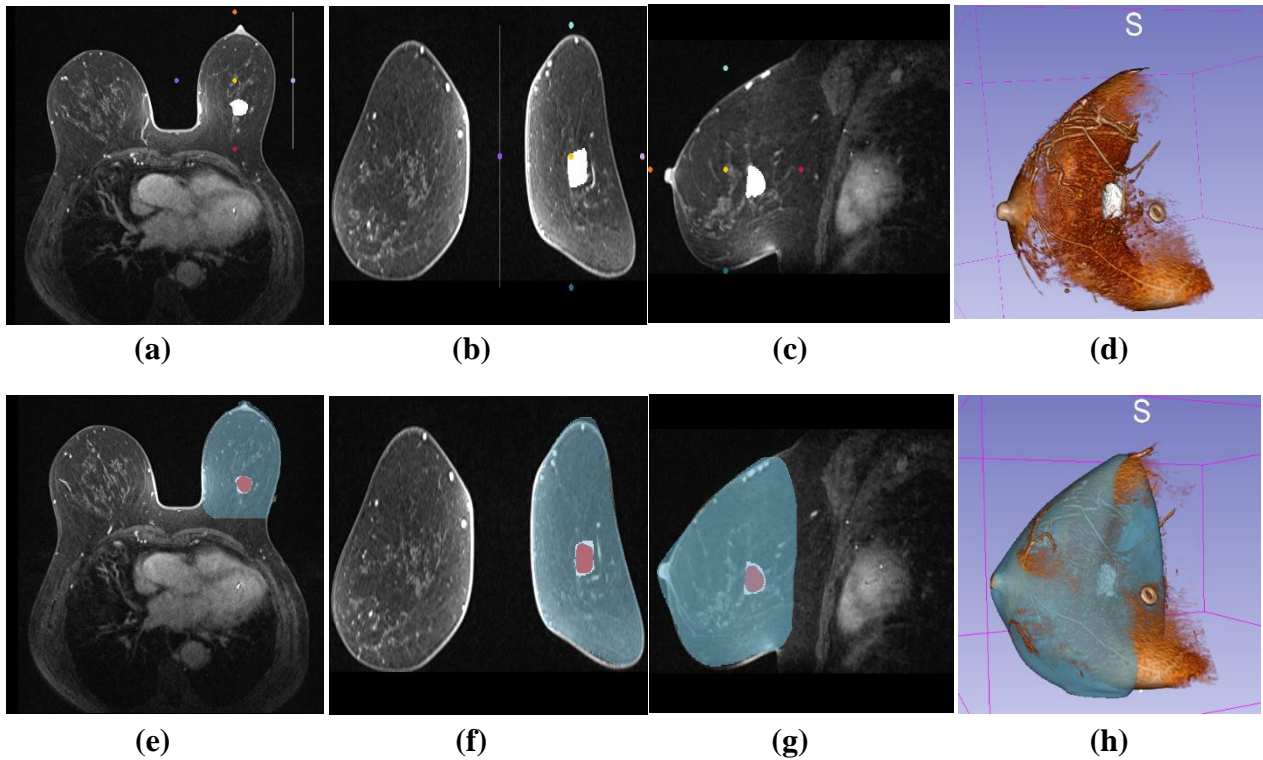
MRI images in 3D slicer in (a) Axial (b) Coronal (c) Sagittal, planes, and (d) ROI in 3D slicer. Figure (e-h) shows a manual segmentation of ROI through surface cut.
